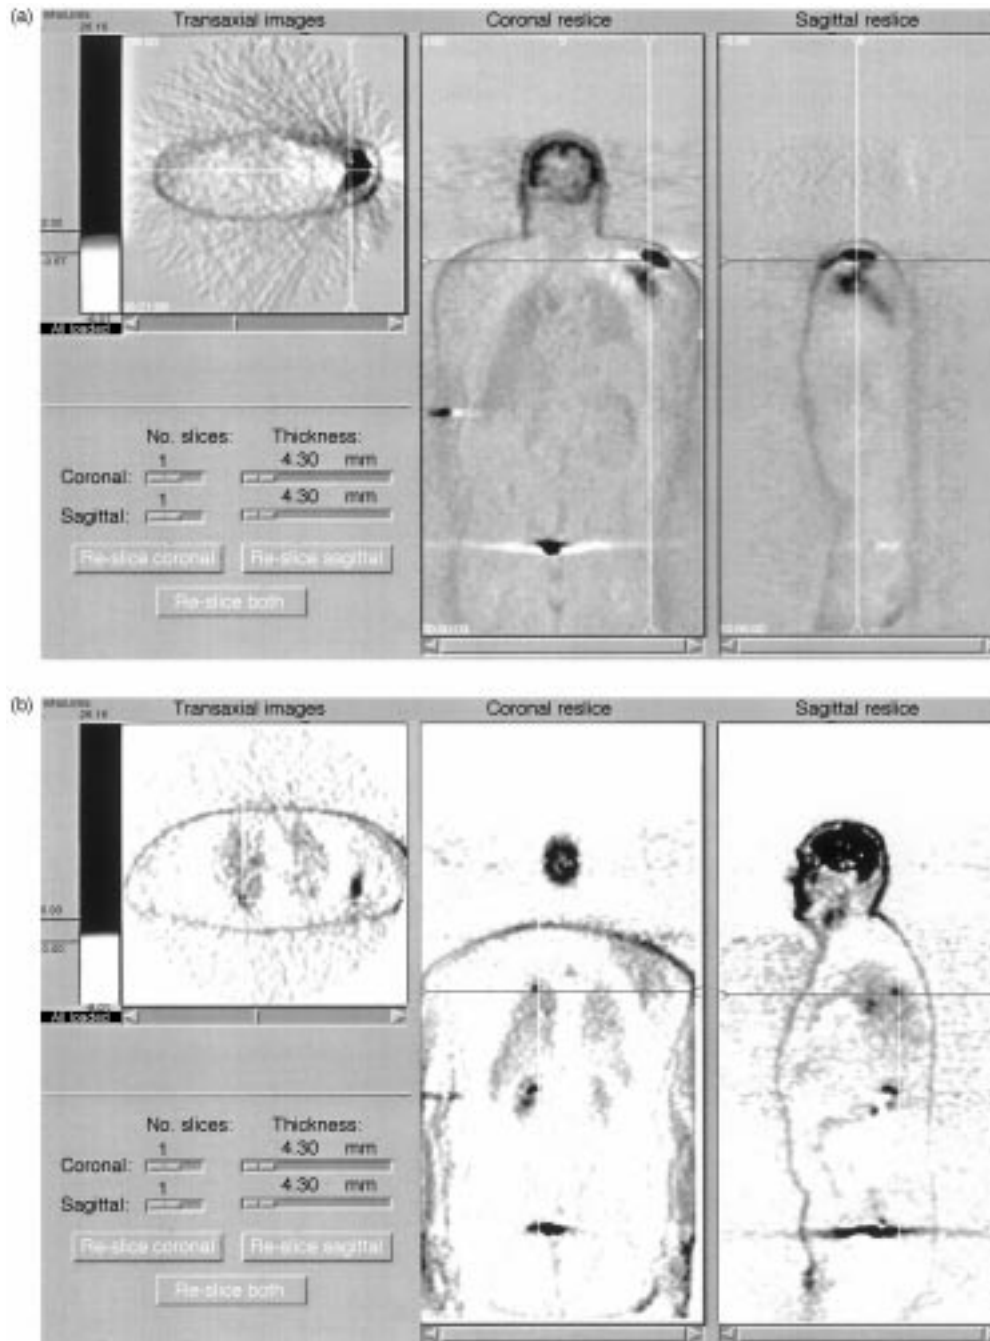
(a) Transaxial, sagittal and coronal PET image of a patients with metastatic adenocarcinoma of the left scapula (a) and a primary lung cancer in the right upper lobe (b) indicated by focal increased FDG uptake (+). Physiological FDG uptake is seen in the brain, salivary glands, kidney and bladder.
